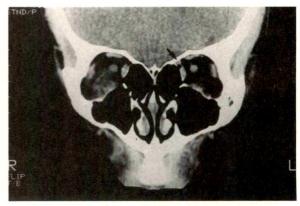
(Matsuo and associates). Case 3. Computed tomography of the orbit showing absence of right superior oblique muscle in coronal section posterior to the globe. Note left superior oblique muscle (arrow).
